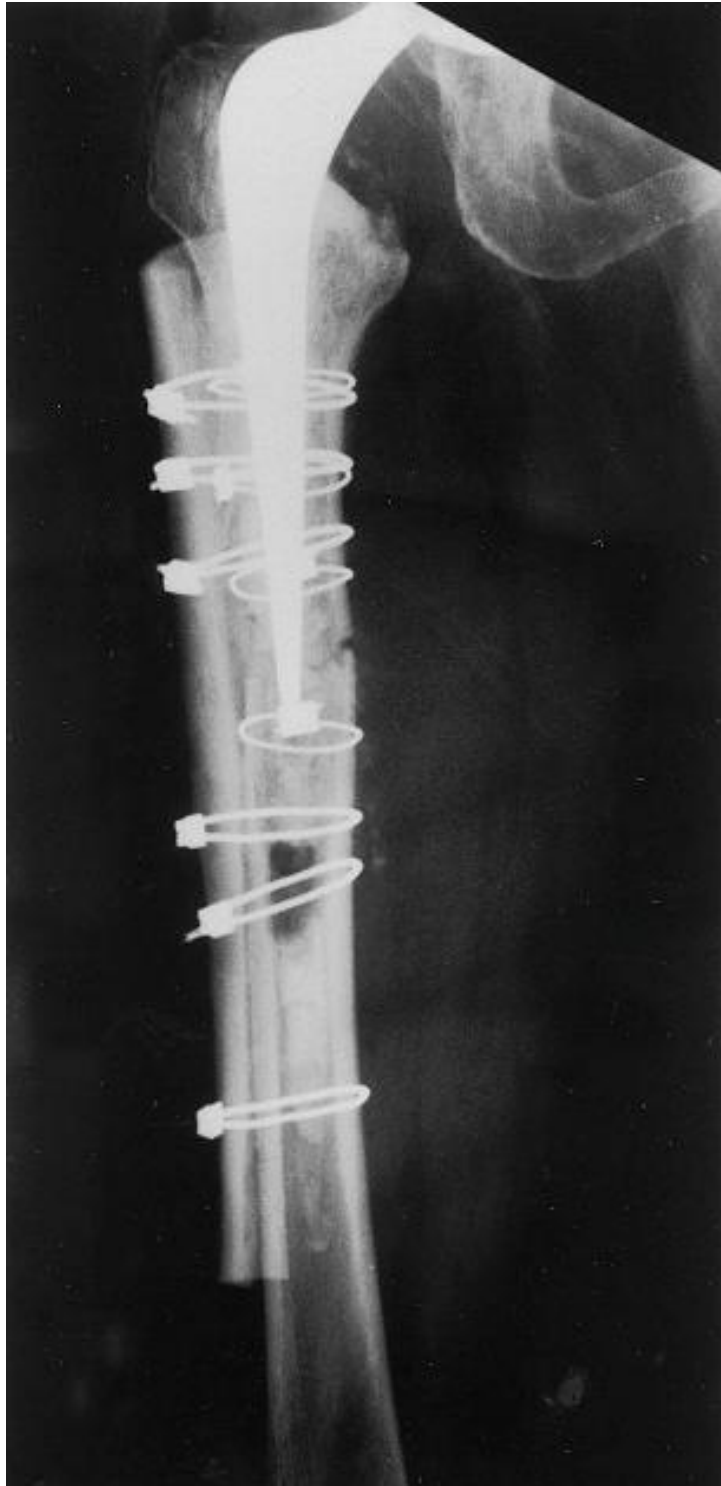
Anteroposterior radiograph of the right hip taken in the immediate post-operative period showing that the fracture was stabilised with use of cortical onlay strut allografts and cables
